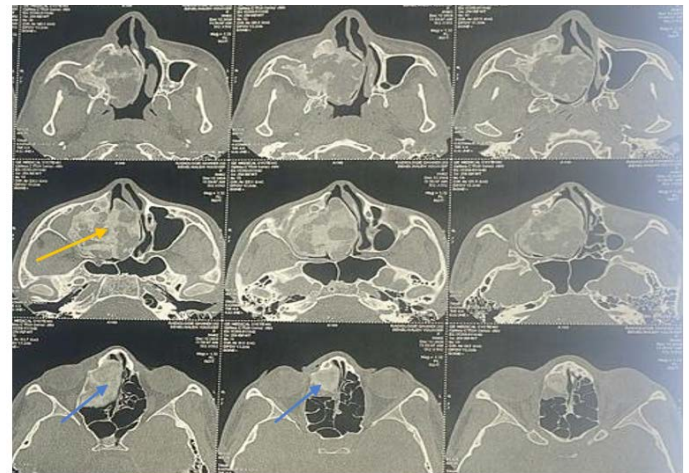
Axial section CT scan showing invasion of the medial wall of the right maxillary sinus, the right middle and inferior turbinate's (yellow arrow) and the right anterior ethmoid (blue arrow).
